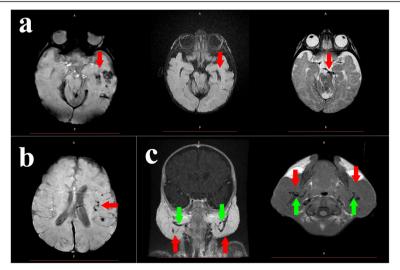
MRI imaging. a *Red arrows* show signal abnormality in the left temporal lobe, quadrigeminal cistern, and ambient cistern with susceptibility artifact on SWAN images showing vascular malformation. b *Red arrow* shows serpiginous blooming artefactual signal in the left cerebral hemisphere consistent with dilated collateral vascular channels. c *Red arrows* show diffusely enlarged parotid glands with signal alteration and green arrows show flow voids in the parenchyma of parotid glands indicating bilateral parotid hemangiomas
